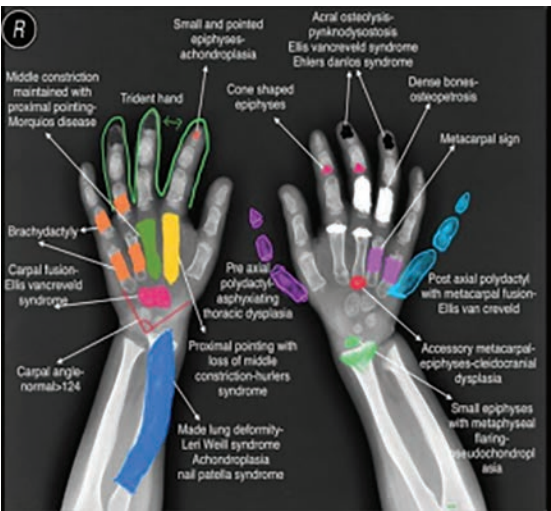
Pathologies in bilateral hand radiograph in osteochondral dysplasias
